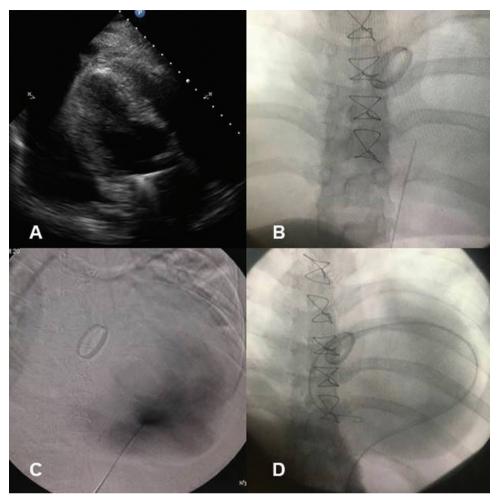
(A) Four-chamber echocardiographic view of posterior pericardial effusion and minimal pericardial fluid at the apex. (B) View of the needle in the right ventricle. (C) View of pericardial effusion with fluoroscopy. (D) Placement of the catheter into the posterior pericardium.
